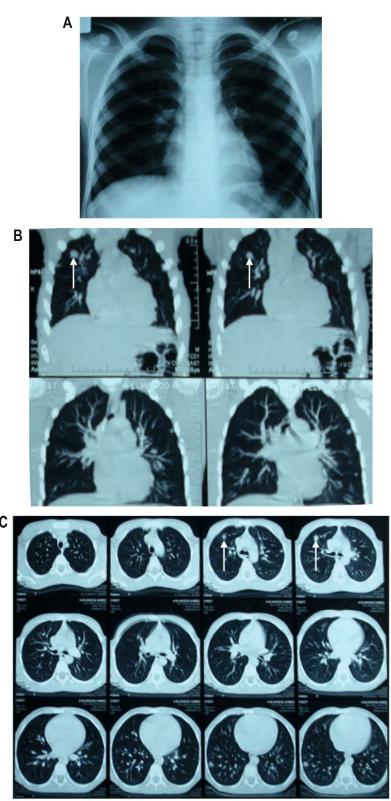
(A) Chest X-ray film showing an infiltrative shadow in both the middle and lower lung fields mainly in the right lung. (B) and (C) CT scan images showing bilateral multiple intra-pulmonary focal lesions. The most predominant two pulmonary nodules demonstrated mainly in the anterior segment of upper lobe and lateral segment of lower lobe of right lung field respectively.
